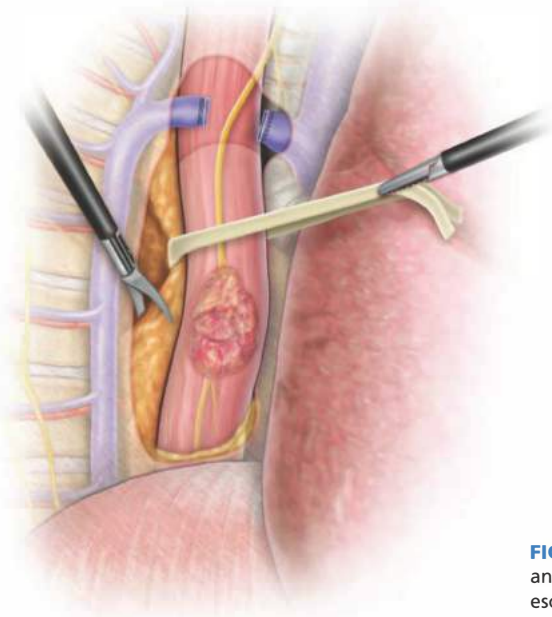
• The mobilization of the intrathoracic esophagus using an ultrasonic dissector. The azygous vein is routinely divided. The esophagogastric anastomosis is usually performed at the level of the azygous vein.
